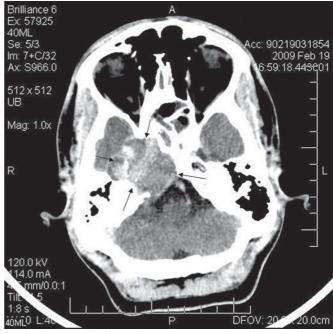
CT scan showing a large space-occupying lesion in the right petrous apex, which was actually the partially thrombosed wall of the giant aneurysm within the carotid canal
